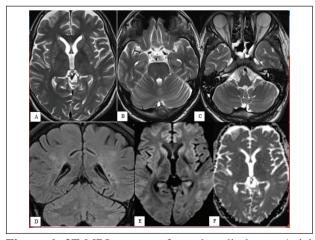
3T MRI scans performed at discharge. Axial T2w images (A, B, C) and coronal Flair image (D) demonstrate prominent regression of the hyperintensities. Axial diffusion-weighted image (E; $b = 2000 \text{ sec/mm}^2$) and the corresponding apparent diffusion coefficient (ADC) map (F) show no restricted diffusion anymore.
